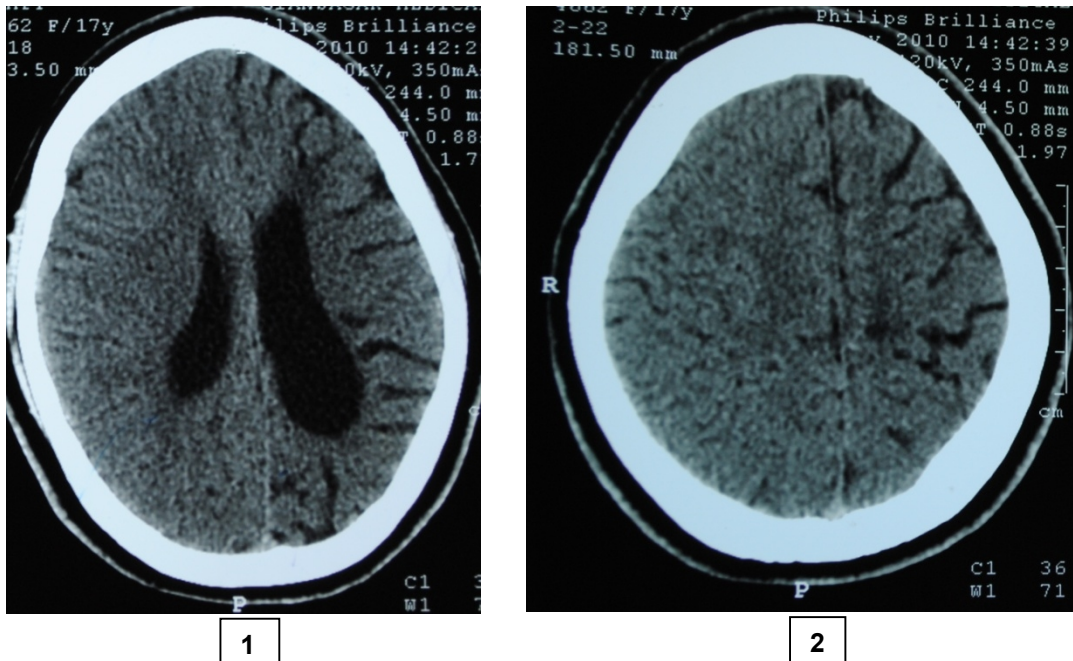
Plain CT images of the brain show left cerebral hemispheric atrophy with left lateral ventricular dilatation and diffuse white matter hypodensities. The falx is seen in the midline with mild thickening of overlying left parietal bone.
